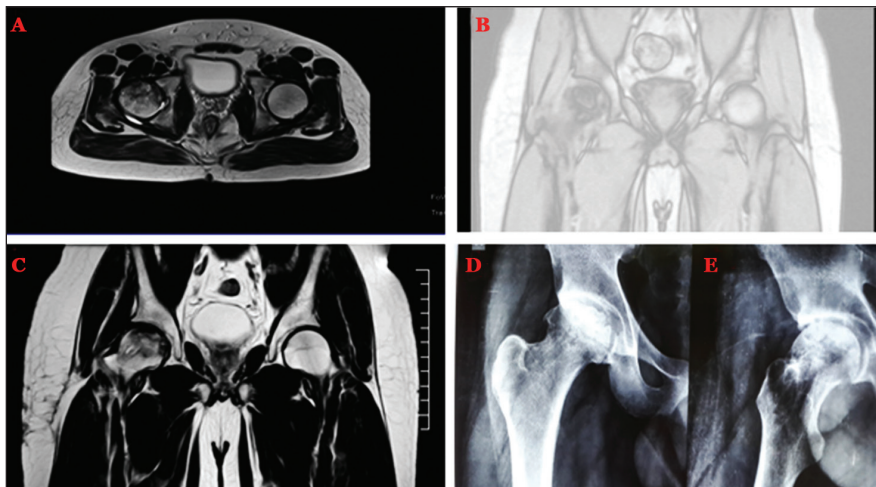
Patient M4. Preoperative magnetic resonance image of Association Research Circulation Osteous stage III of the right hip. Extensive involvement of the central and lateral regions (>50%), with the crescent having less than 2 mm of depression (A, B). Magnetic resonance image at 5 months after treatment (C). Preoperative anteroposterior radiograph (D). Anteroposterior radiograph at 6 years after treatment showing no further progression, with evident intramedullary changes. The joint space is preserved, which is consistent with good clinical function (E).
